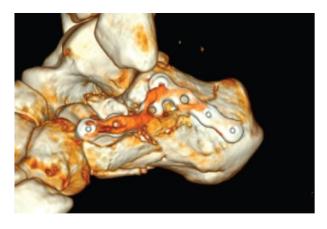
Postoperative computed tomography scan of Sinus tarsi locking plate fixation.
